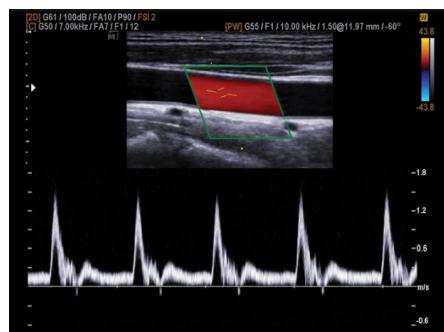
Duplex ultrasound image and spectral; Doppler.
